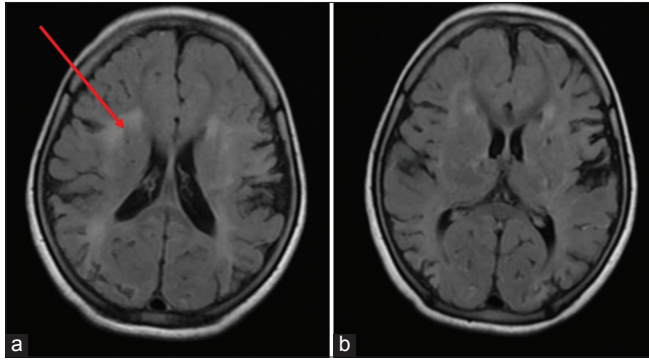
(a) Axial fluid attenuation inversion recovery (FLAIR) image showing ischemic changes in bilateral frontal (arrow) and parietal white matter; (b) Axial FLAIR image showing gliosis in the left parietooccipital lobe and lacunar infarcts in the left capsuloganglionic region
